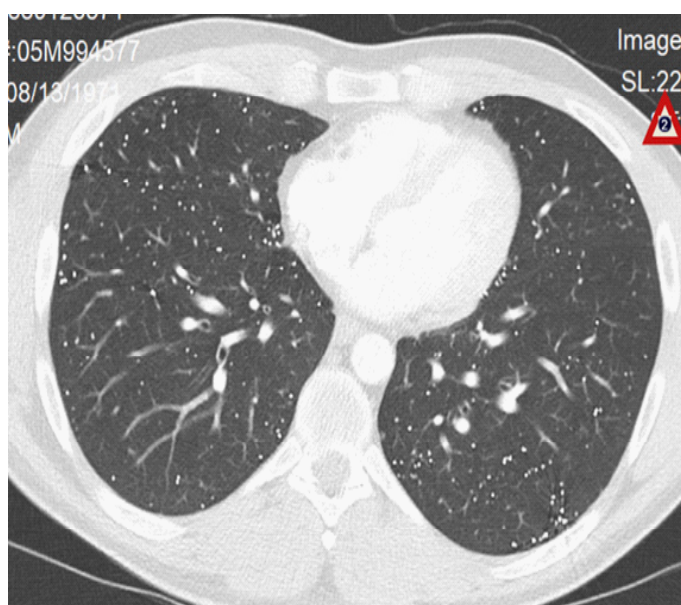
Cross-sectional view of CT chest showing refractile particles.
